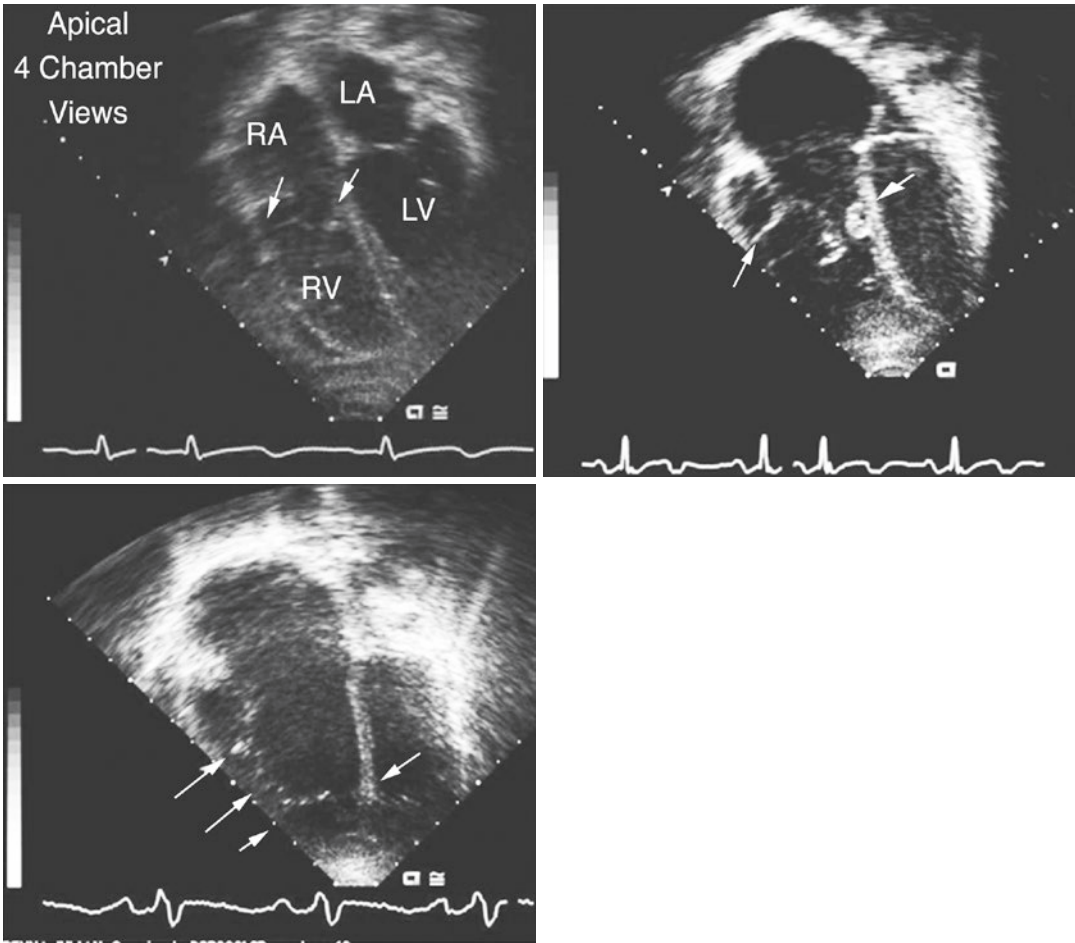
This series of apical four-chamber images shows the progressive displacement of the tricuspid septal leaflet with progressive severity of the disease. In this view the anterior and septal leaflets are demonstrated. *Top Frame:* The right atrium (RA) in the top frame is minimally enlarged, as is the right ventricle. Note the attachment of the anterior leaflet is normal in all of these frames. The lateral *arrows* indicate the chordae tendinae, attached to the right ventricular wall. The medial *arrows* indicate the septal attachment of the tricuspid valve. The mitral valve for comparison lies between the left atrium (LA) and left ventricle (LV). *Middle Frame:* This shows a moderate degree of displacement of the septal leaflet of the tricuspid valve (*Medial arrow*). The lateral *arrow* indicates thin attachment of the tendinous cords underneath
